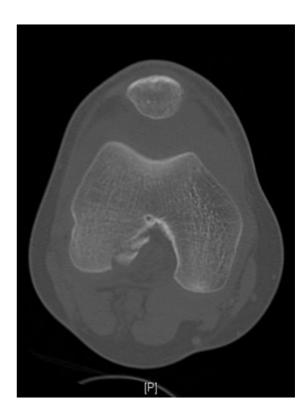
Axial computed tomography image shows comminuted femoral avulsion fracture from the lateral portion of the intercondylar notch. A large knee effusion is forcing the patella away from the femoral groove.
